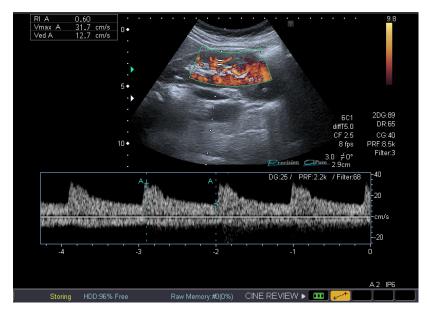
Ultrasonorgaphy image of a patient from the 1st group. No signs of intrarenal hemodynamic impairment have been registered.
